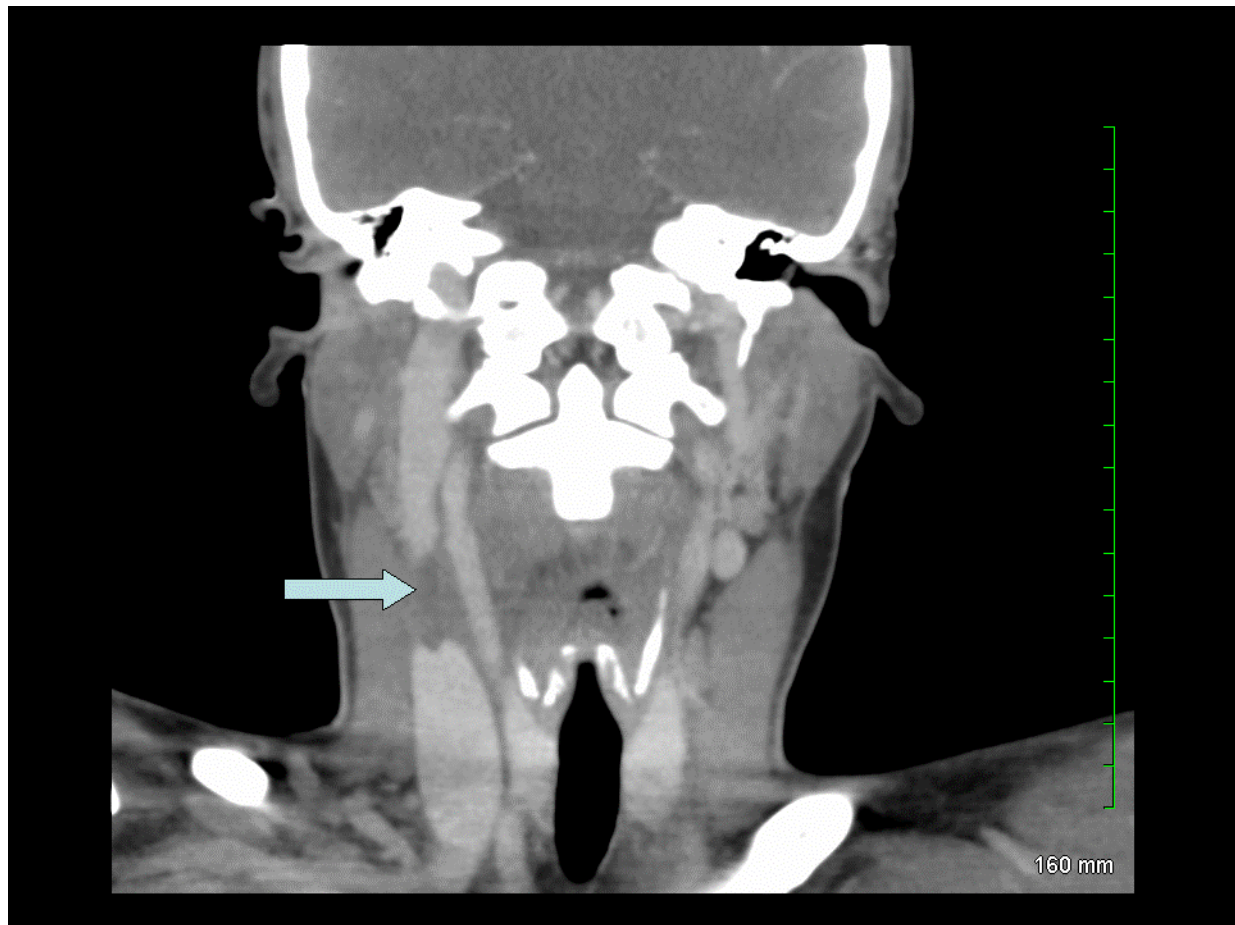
CT of the neck with contrast: nonocclusive soft tissue filling defect extending over 2 cm is consistent with a thrombus seen within the right internal jugular vein at the level of the hyoid bone (arrow).
